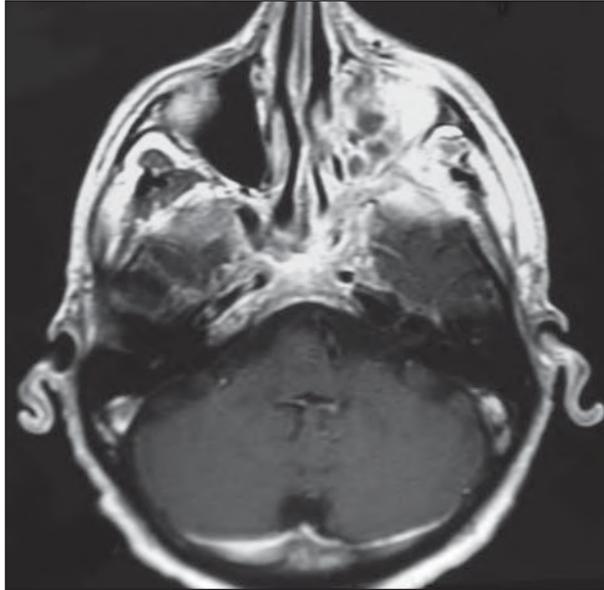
Preoperative axial magnetic resonance image demonstrates extensive squamous cell carcinoma of the left maxillary sinus with extension into the skull base.
